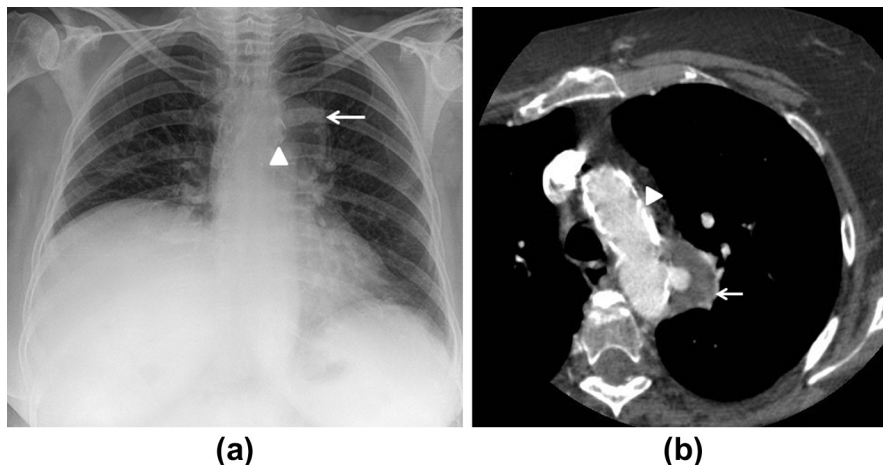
(a) Chest radiograph showing focal dilatation of the aortic arch (arrow), the aortic calcification is demonstrated medially. (b) Transaxial CT imaging showing the penetrating ulcer with associated IMH.
